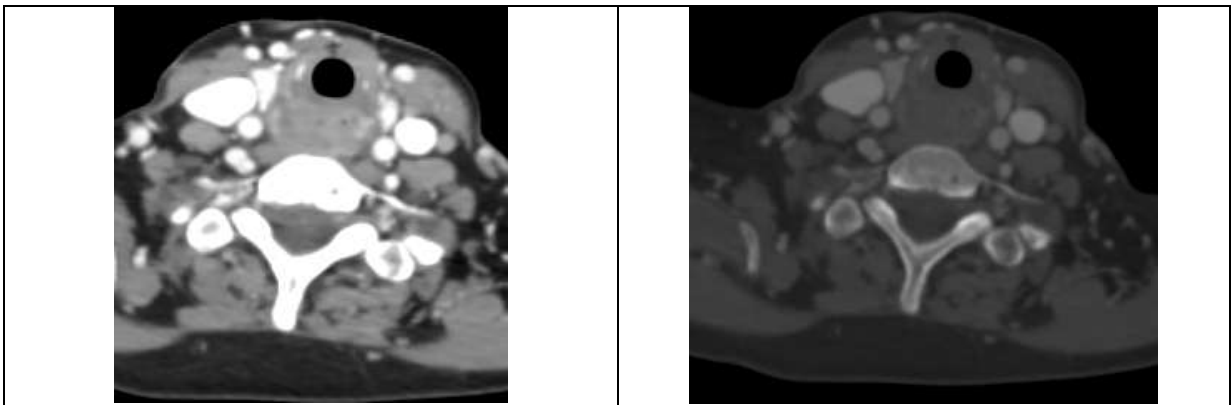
(a) and 10(b): Axial CECT and CT bone images at the level of cricoid cartilage in a case of Ca hypopharynx shows invasion of cricoid cartilage
